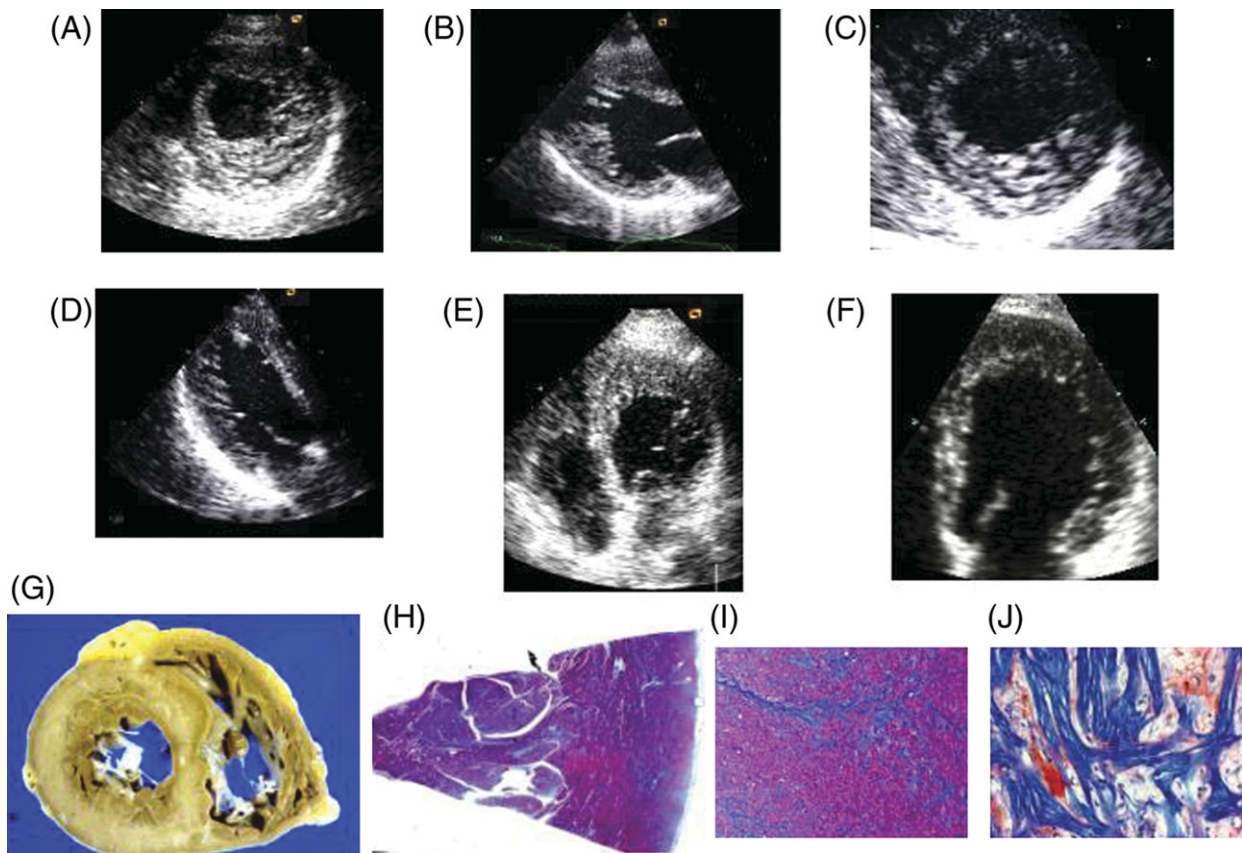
Images of patients from Family 1. (A) Echocardiographic parasternal short axis apical view of the index (IV:26, 15 years old) showing marked posterolateral trabeculation with a thin epicardial compact layer. (B) Parasternal short axis view patient IV:10 with prominent apical trabeculation. (C) Midventricular short axis view patient IV:16 with postero-inferior trabeculation. (D) Apical three-chamber view of IV:11 with posterior wall trabeculation. (E) Apical four-chamber view III:14 showing apical hypertrophy with deep invaginations. (F) Apical four-chamber view III:12 mild trabeculated hypertrophy. (G) Transversal section of the explanted heart of III:2 showing concentric hypertrophy and prominent fibrosis. (H) Macro-micro of the same heart showing moderate trabeculation. (I) Details of the fibrosis in the same patient. (J) Marked fibre disarray in the same patient.
